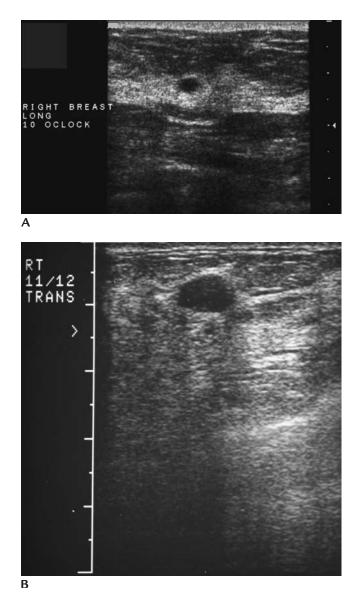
(A) Note positioning of the focal zone (*arrowhead*) and labeling of the image. When using the single focal zone, placing it close to the lesion for maximum resolution is helpful. Depending on the size of lesion, multiple focal zones may be needed. The 10 o'clock position can encompass a significant amount of tissue in some patients; therefore, giving an approximate distance from the nipple (or describing a zone) can be helpful particularly if a follow-up ultrasound is recommended. (B) Note focal zone position, field of view and labeling of image.
